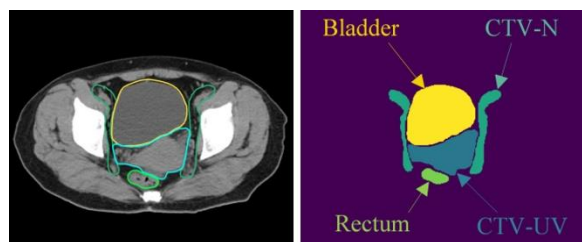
Regions delineated in cervical cancer CT images.
